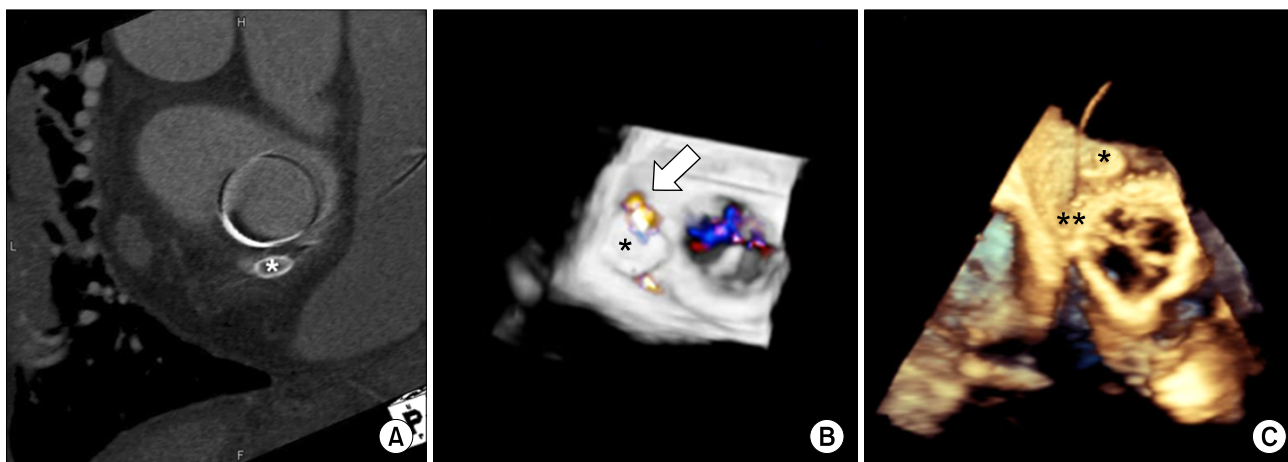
(A) Enhanced computed tomography findings and (B) three-dimensional transesophageal echocardiography after the first attempt at transcatheter device closure. Remnant paravalvular leakage (arrow) and the vascular plug device (*) that was inserted in the first attempt can be seen. (C) Three-dimensional transesophageal echocardiography shows two vascular plug devices: the first device (*) and the second device ().
